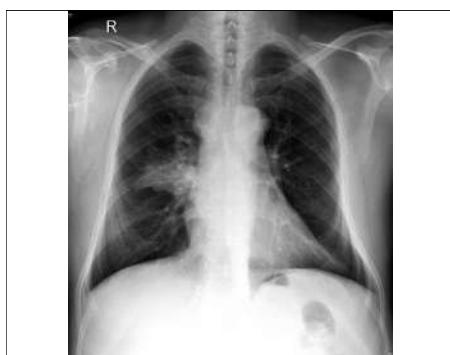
Chest x-ray showing infiltration in the right middle zone with evidence of partial (segmental) lung collapse.
